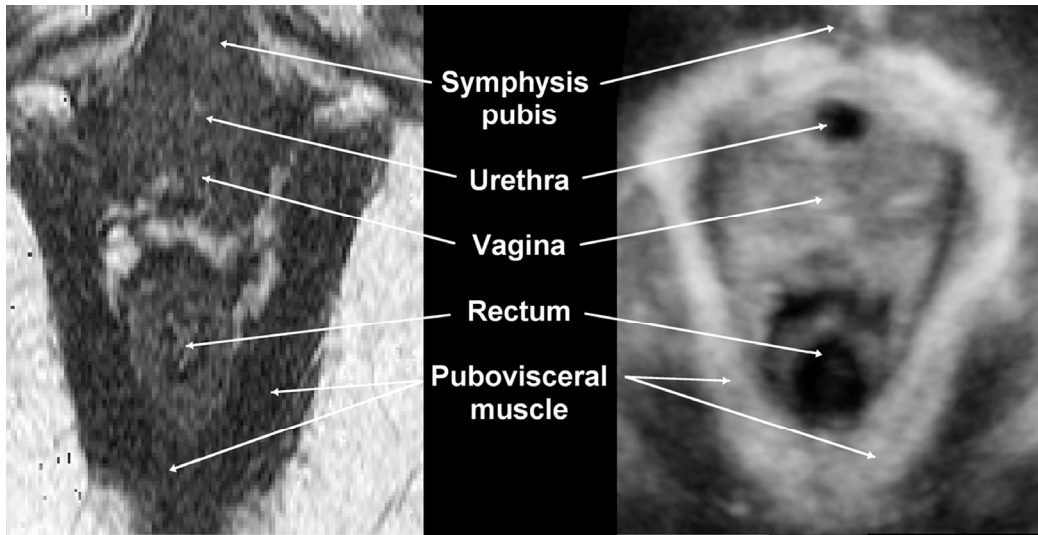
Comparison of MRI (left) and volume translabial ultrasound (right) of the puborectalis/pubococcygeus complex in a young asymptomatic volunteer (MRI image courtesy of J. Kruger, Department of Sports and Exercise Science, Auckland University).
